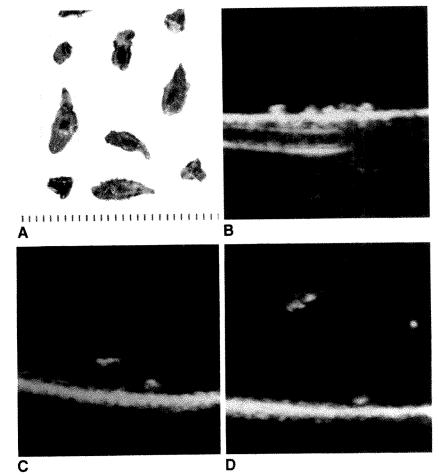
Gross appearance and sonograms of adult worms of C. sinensis collected from feces of patient in Fig. 1. Sonograms were obtained with worms in saline solution in surgical glove. A 3.5-MHz transducer was used.
